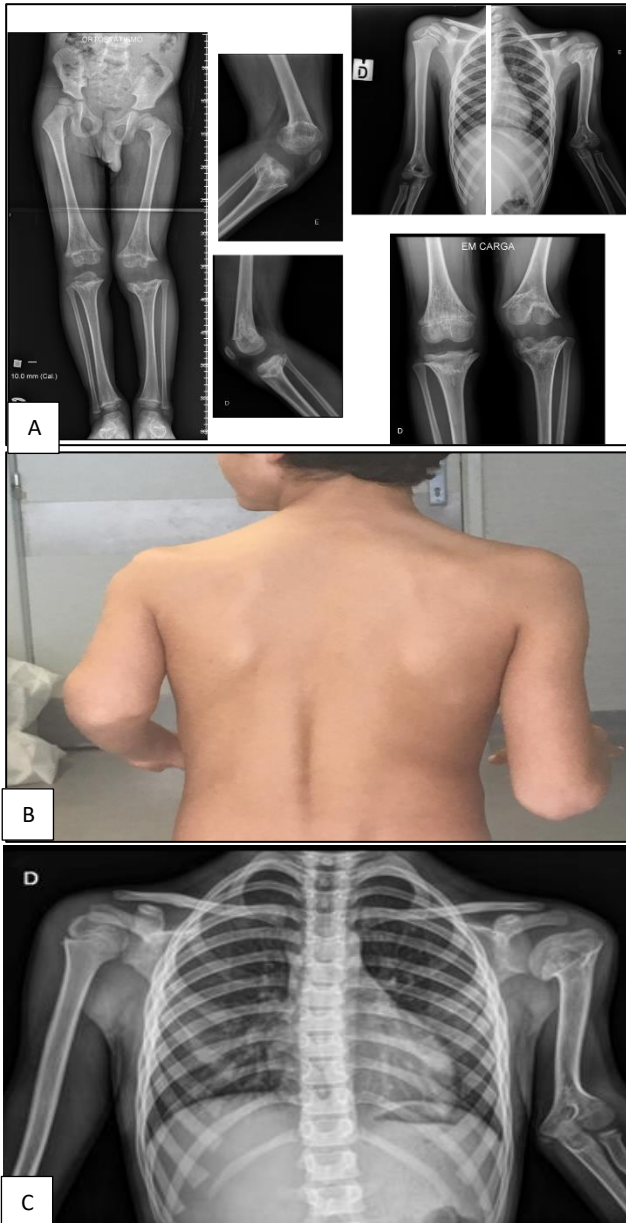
(A-C): Patient 4; full length lower limb radiograph; antero-posterior and lateral radiographs of the knees; antero-posterior radiographs of the shoulders; posterior picture of the patient and antero-posterior radiographs of the shoulders.
